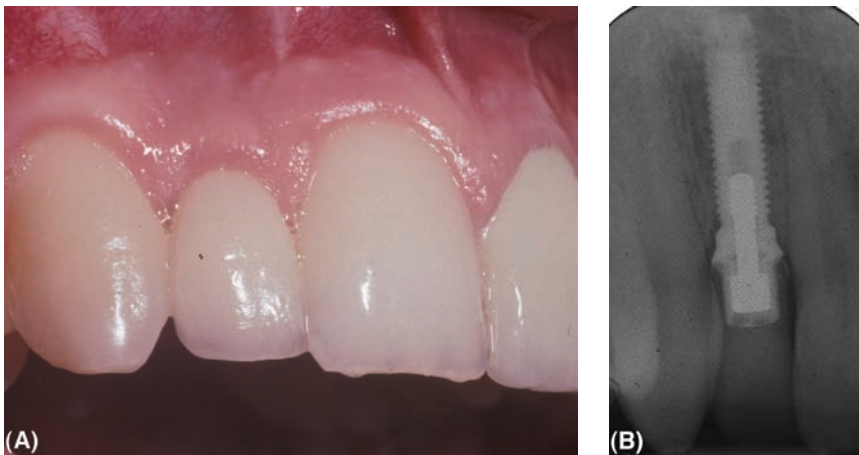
(A) Replacement of a small upper lateral incisor with a single tooth implant showing good soft tissue form and aesthetics. (B) Radiograph of the single tooth implant, which in this case is a narrow diameter (3.3 mm) Nobel Biocare implant. Narrow implants are normally only suitable for low load situations.
